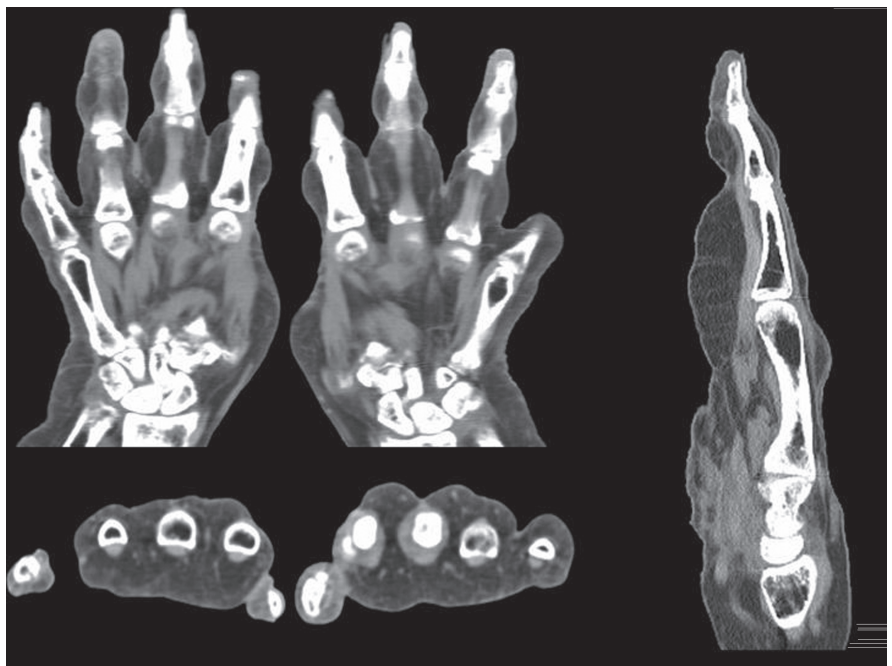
CT scan of the hands: presence of subcutaneous unencapsulated fatty tissue.
